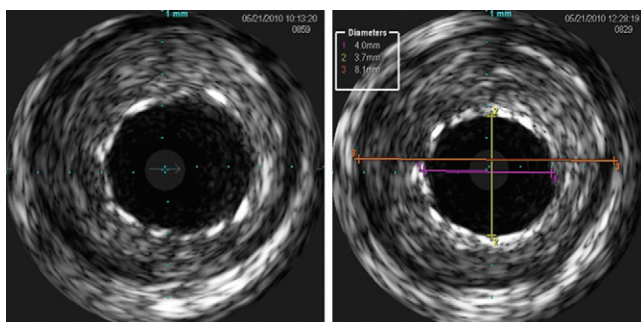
Intravascular ultrasound (IVUS) measurements made after stent implantation.
